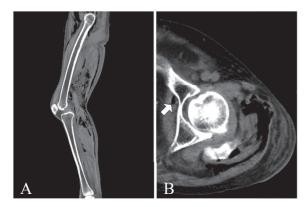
Sagital view and axial view of extremities computed tomography (CT) without contrast. (A) It displayed extensive subcutaneous emphysema of left lower extremity mimic gas-forming myonecrosis (GFM). (B) It showed air existed in the pelvic cavity (arrow) provided a clue that the gas of the left lower extremities may originate from pelvic cavity.
